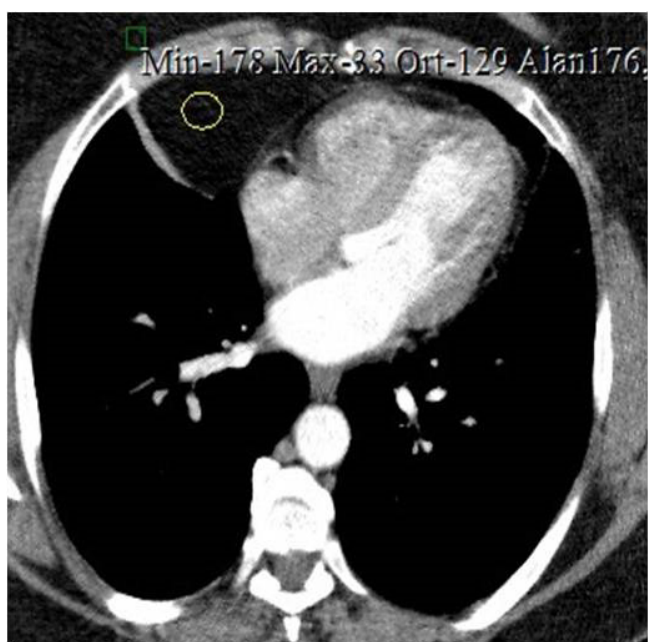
(-) 129 HU density (fat) were measured in the right cardiophrenic sinus and compression atelectasis were noted due to cardiophrenic fatty tissue in the axial contrast enhanced thorax CT.
